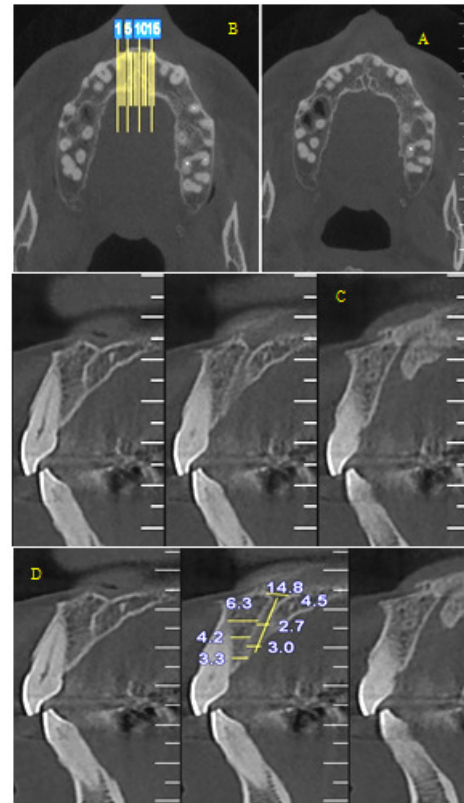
A: Axial image of nasopalatine canal, B: Thickness of slices (1mm), C & D: Measurement of height and diameter of canal in cross-sectional CBCT images
